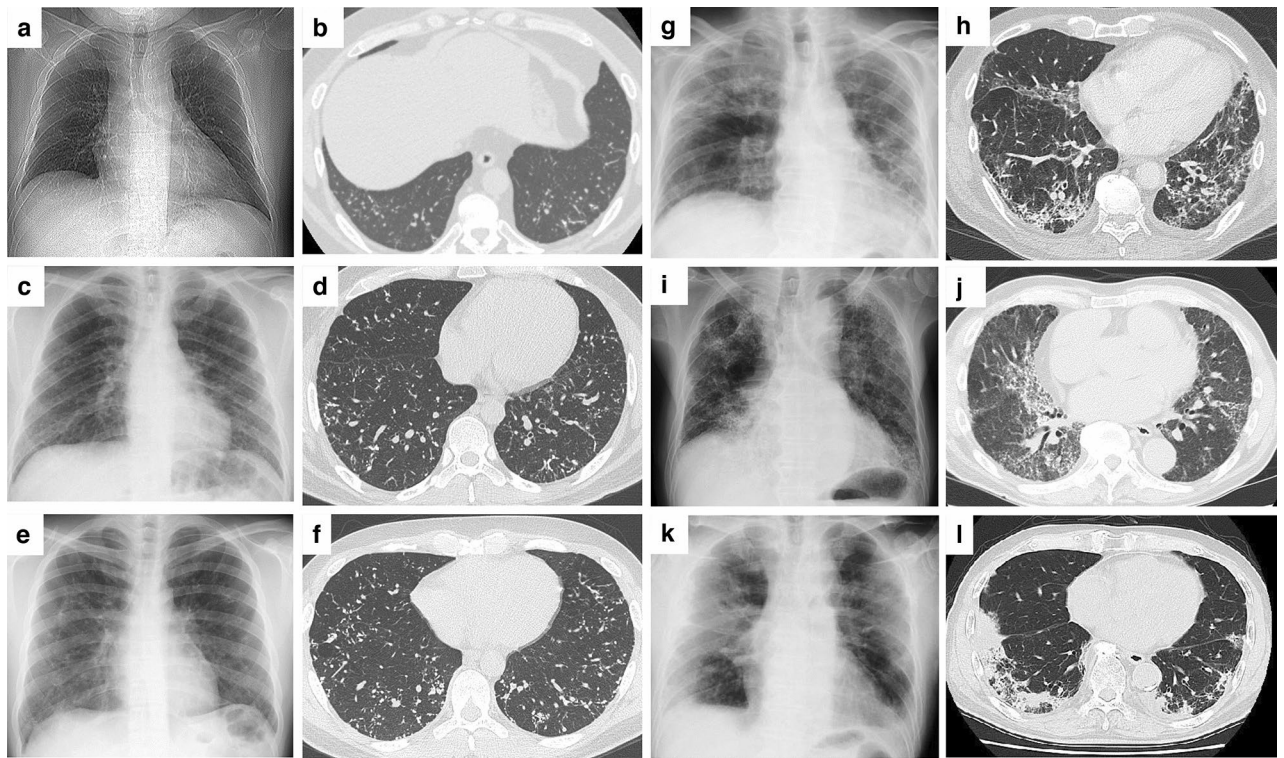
Radiological findings of lung lesions detected in three patients with I-DiPO and three patients with S-DiPO. Three patients with I-DiPO had low (calcified total score = 3; a, b, Patient 3), medium (score = 4; c, d, Patient 10), and high (score = 5; e, f, Patient 28) levels of calcified lesions. The calcified total score represents the sum of grades from three assessment items for calcified lesions: fine calcified nodules, calcified short lines, and calcified branching structures. Three patients with S-DiPO had ossified lesions associated with IP (g, h, Patient 12) and ossified lesions associated with Af and IP (i, j, Patient 31; k, l, Patient 24). (a, c, e, g, i, k) Chest radiographs; (b, d, f, h, j, l) computed tomography horizontal sections under lung window settings. Af Atrial fibrillation, I-DiPO idiopathic diffuse pulmonary ossification, IP interstitial pneumonia, S-DiPO secondary diffuse pulmonary ossification.
